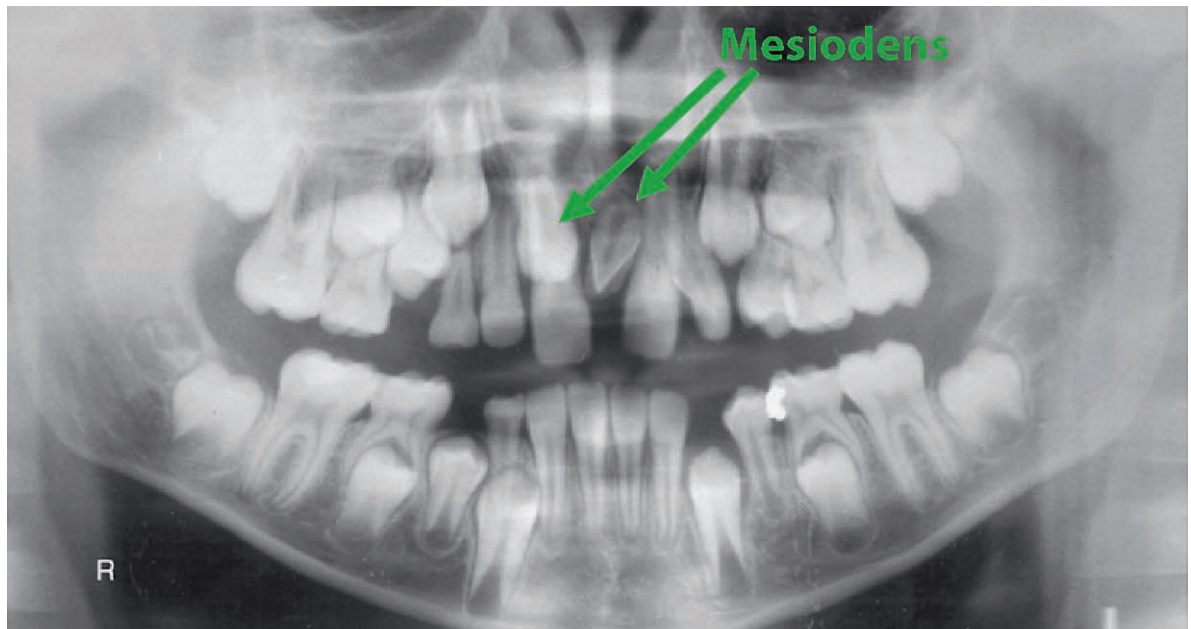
Unerupted mesiodens (arrow on panoramic radiograph) is causing displacement of the adjacent regular central incisors. Uncommonly (photograph) there is room for the mesiodens to erupt and “function”
